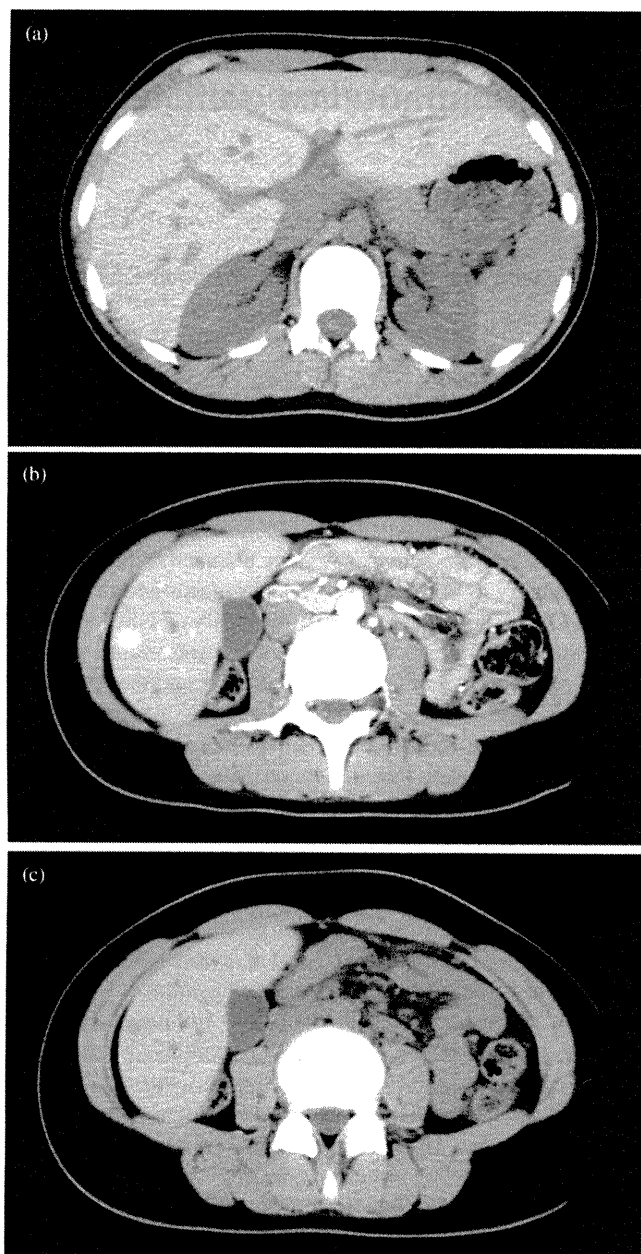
(a) The findings of a plain abdominal computed tomography (CT) scan at 5 years of age. The CT value of the liver was markedly elevated compared with that of the spleen and kidneys. (b) The findings of the early phase of a contrast-enhanced abdominal CT scan at 15 years of age showing an enhanced lesion. (c) The findings of the same section as (b), without contrast enhancement.
